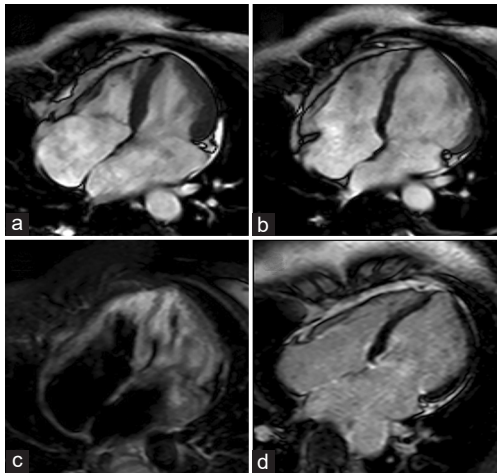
Cardiac magnetic resonance imaging performed at 3-month follow-up. Cine images performed along the four-chamber view in end-systole (a) and end-diastole (b) show complete recovery of midventricular akinesia. T2-weighted short-time inversion recovery (c) and T1-weighted phase-sensitive inversion recovery images (d) performed along the same plane, respectively, showing normalization of myocardial signal and no evidence of late gadolinium enhancement
